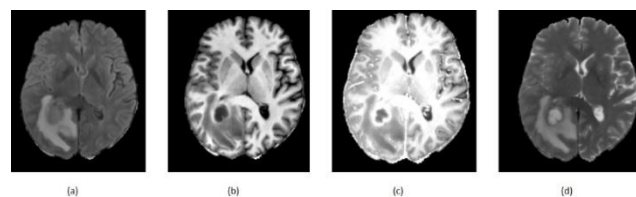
Multimodal MRI scans of glioma (a) FLAIR (b) T1 weighted (c) post contrast T1 weighted (d) T2 weighted.
